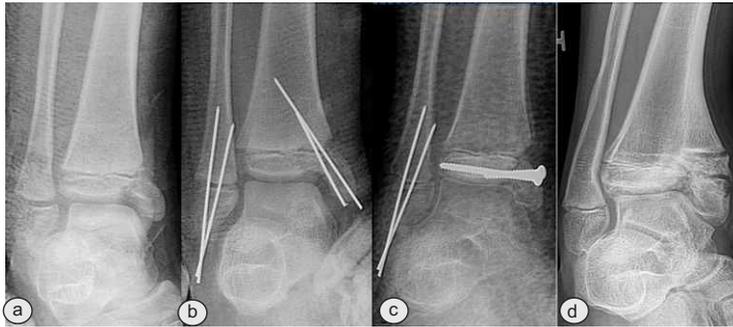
Case1: a- Ankle radiograph showing Salter Harris Type III fracture of medial part of tibia and SH Type I fracture of distal fibula. b- Closed reduction and K wire fixation done. The medial malleolus appeared to be rotated and displaced. c- Opening of medial malleolus demonstrated that it was a type IV SH fracture. Reseat surgical fixation was done using cancellous screws. d- One year post surgery radiograph showing varus deformity and bony bar formation..
